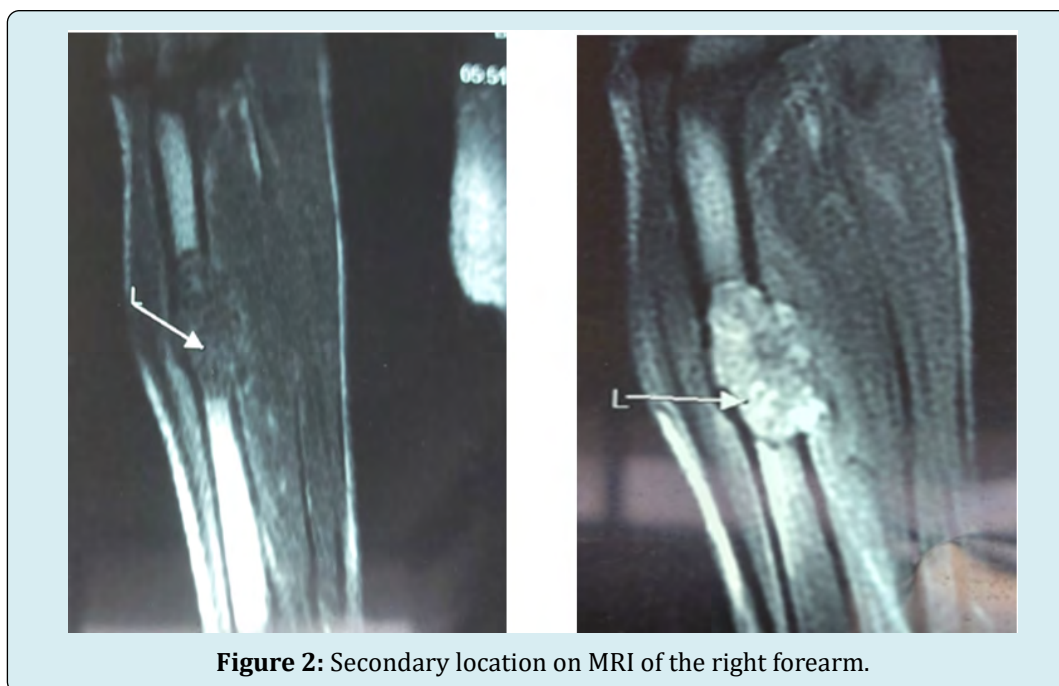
Secondary location on MRI of the right forearm.
